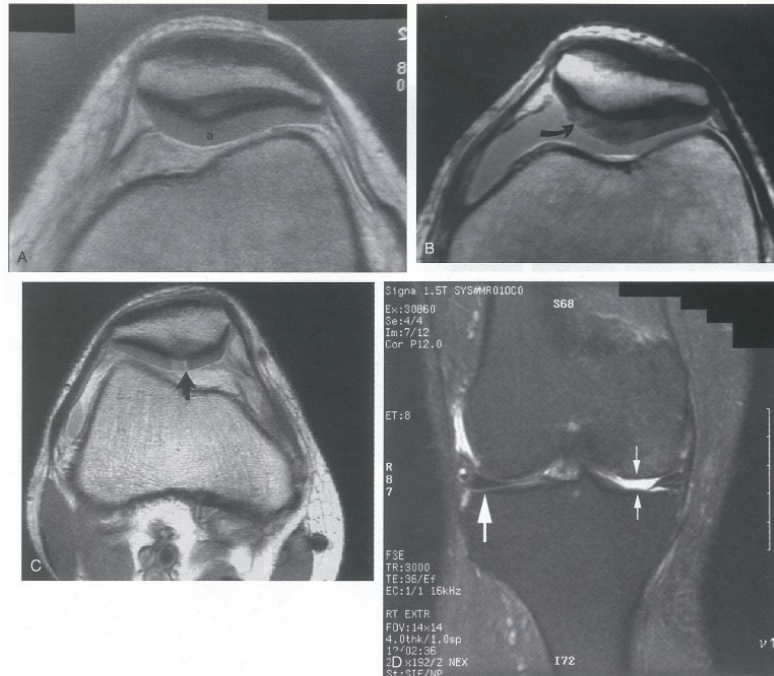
> A Axial magnetic resonance imaging (MRI) shows normal articular cartilage (a) on the patella facets. The cartilage has a uniform signal thickness and appearance. B, Axial MRI reveals fissuring and fibrillation of articular cartilage on the medial facet of the patella (arrow). C, Axial MRI with advanced chondromalacia of the patella. The signal irregularity extends to the subchondral bone, and a deep fissure is identified (arrow). D, Coronal MRI demonstrates complete loss of the articular cartilage of the medial compartment (thin arrows). For comparison, the gray band of articular cartilage on the lateral tibial plateau is also identified (thick band).
